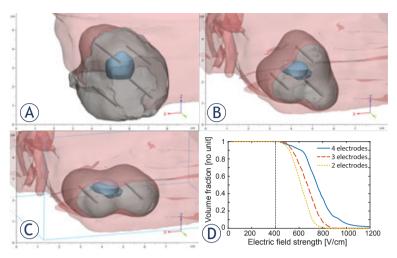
Numerical visualization of electric field for successful electrochemotherapy. (A) Reconstruction of actual treatment based on cone-beam computed tomography (CBCT) images. (B) 3 electrode treatment plan based on pre-treatment CECT. (C) 2 electrode treatment plan based on pre-treatment CBCT. (D) Electric field histogram showing the volume fraction of tumor tissue covered by electric fields of at least the strength indicated on the horizontal axis for all three treatments shown in panels A-C.
